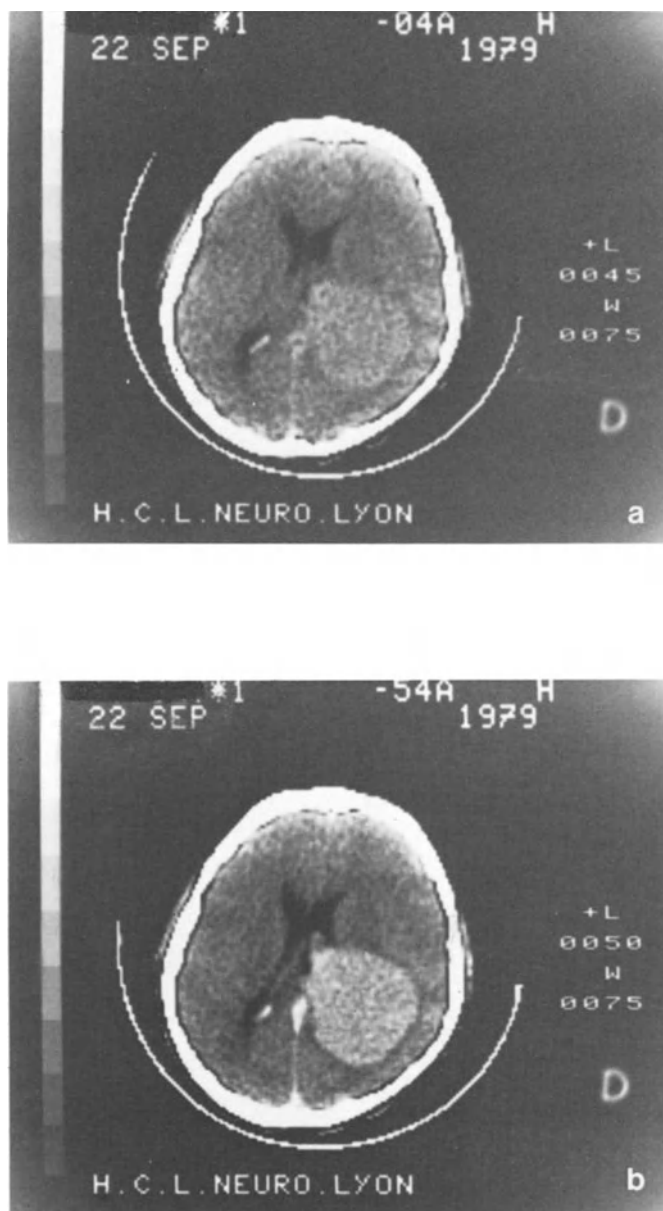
Right atrial meningioma. a) Pre-contrast CT displays a large mass with slightly increased density. b) Post-contrast CT: marked enhancement
